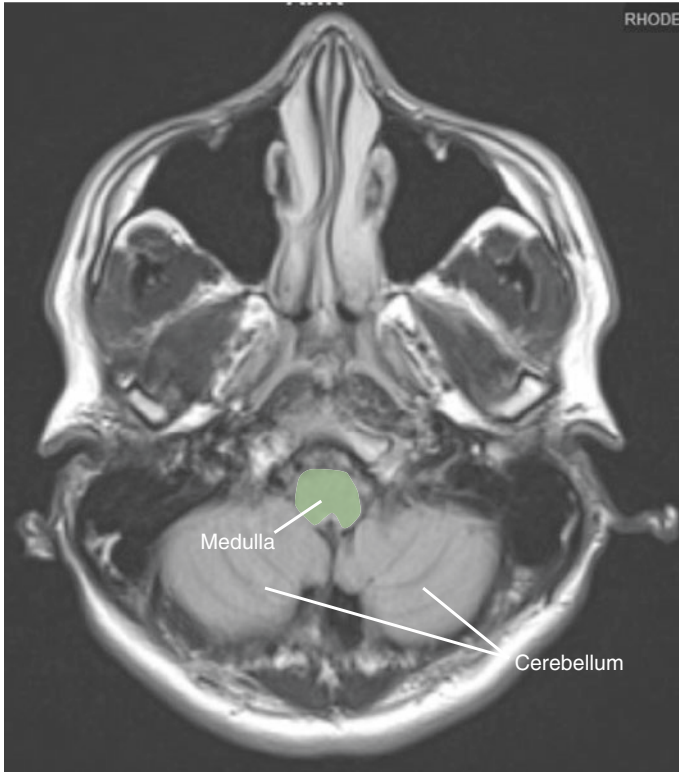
Medulla and posterior fossa (Flair sequence MRI brain)
